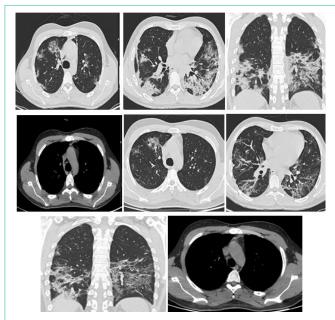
CT on admission: multiple, bilateral, partially confluent consolidations especially in lower lobes, associated with lobular GGO, "crazy paving" pattern and pneumomediastinum. Follow- up CT at 7 days: no significant consolidations in left lower lobe replaced by fibrotic streaks and bands. Mild reduction in extension of consolidations in right lower lobe. No more pneumomediastinum.
